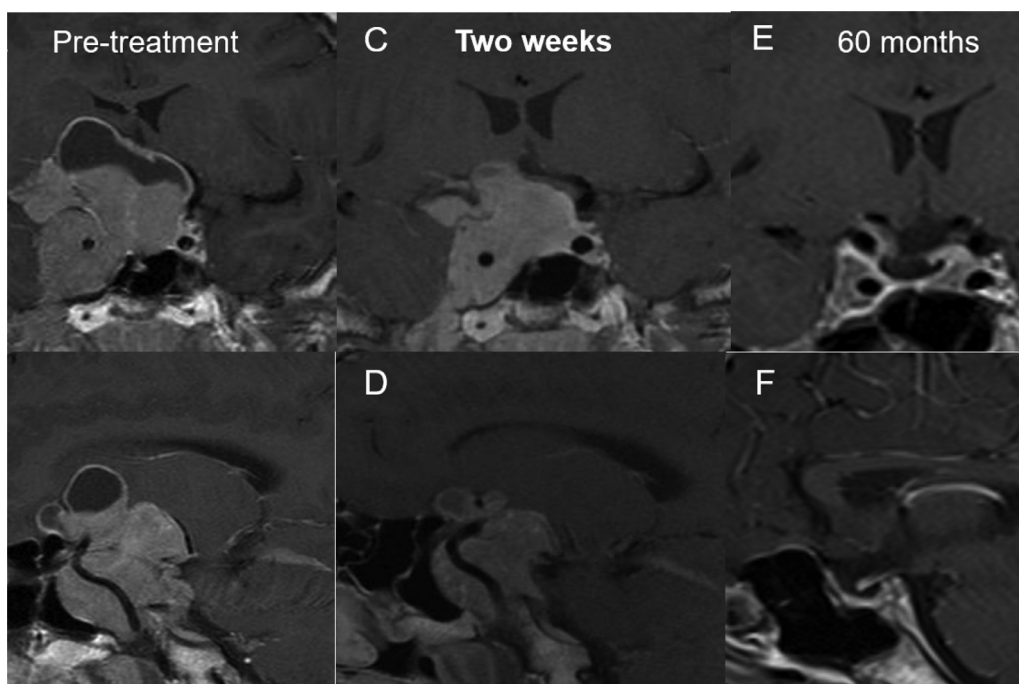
MRI showing tumor reduction of a giant prolactinoma following cabergoline treatment. A 12-year-old boy with amaurosis at right eye and temporal hemianopsia at left eye, presenting a $4.1 \times 5.1 \times 4.4$ cm (volume: 47.7 cm^3 - A and B) macroprolactinoma and prolactin levels 7.674 mcg/L (NR: 2–15.2). After two weeks of treatment, prolactin levels reduced to 159 mcg/L and tumor showed a 52% reduction (volume 22.9 cm^3 - C and D). Prolactin normalized (9.4 mcg/L) after two months and visual field improved progressively. After 60 months, patient is controlled with cabergoline 0.5 mg/week (prolactin 15.3 mcg/L - E and F) and with normal visual field.
